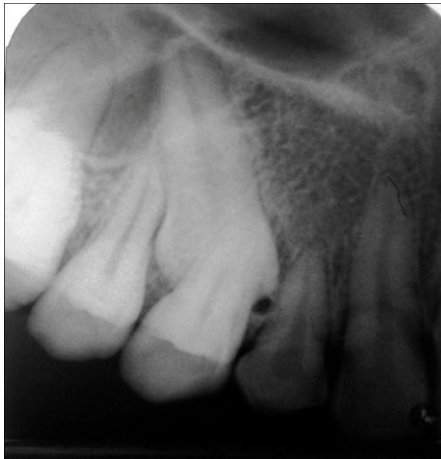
Intraoral periapical radiograph
